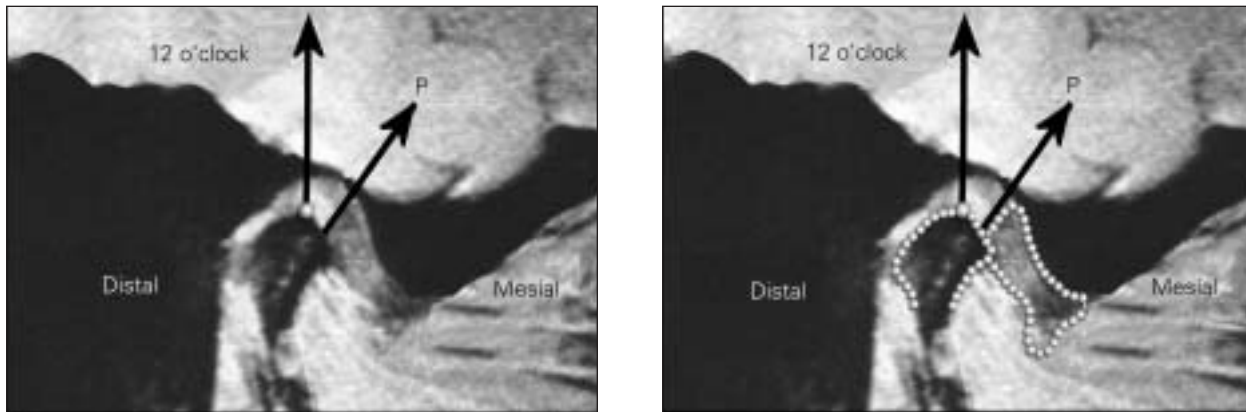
MRI of pretreatment disc displacement during maximum intercuspation. The P ray represents the posterior band of the disc. Note that the posterior band of the symptomatic disc is abnormally displaced mesial to the normal 12 o'clock position. This MRI diagnostic criterion indicates the presence of anterior disc displacement. In the figure on the right, the mandibular condyle and the articular disc are traced for better orientation.
